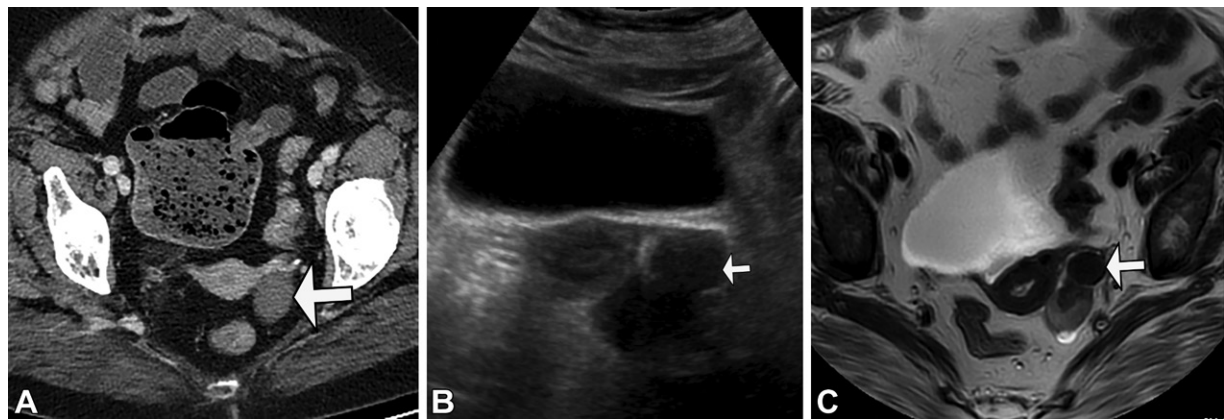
Incompletely evaluated cystic lesion at CT in a postmenopausal patient that requires additional characterization. (A) Axial CT image obtained through the pelvis during a venous run-off study with images obtained only every 5 cm shows a hypoattenuating lesion measuring 42 HU (arrow) in the left ovary. (B) Transabdominal US image obtained for additional characterization shows a hypoechoic bilobed lesion in the left ovary. The anterior portion of the lesion is hypoechoic and appears solid (arrow) while the posterior portion appears anechoic and cystic. The patient could not tolerate transvaginal imaging. (C) Axial T2-weighted MR image shows a bilobed left ovarian mass that has a hypointense component anteriorly (arrow) and a partially cystic component posteriorly. Postcontrast MR images showed mild enhancement (not shown). Pathologic analysis results confirmed a sex cord stromal tumor.
